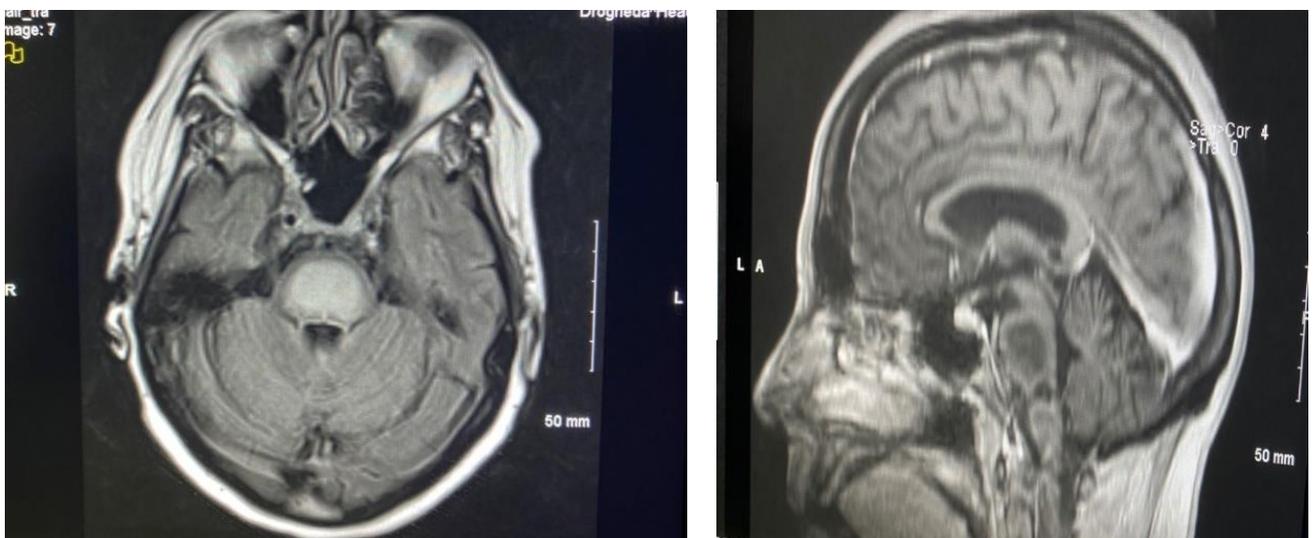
MRI brain T2 pre contrast
